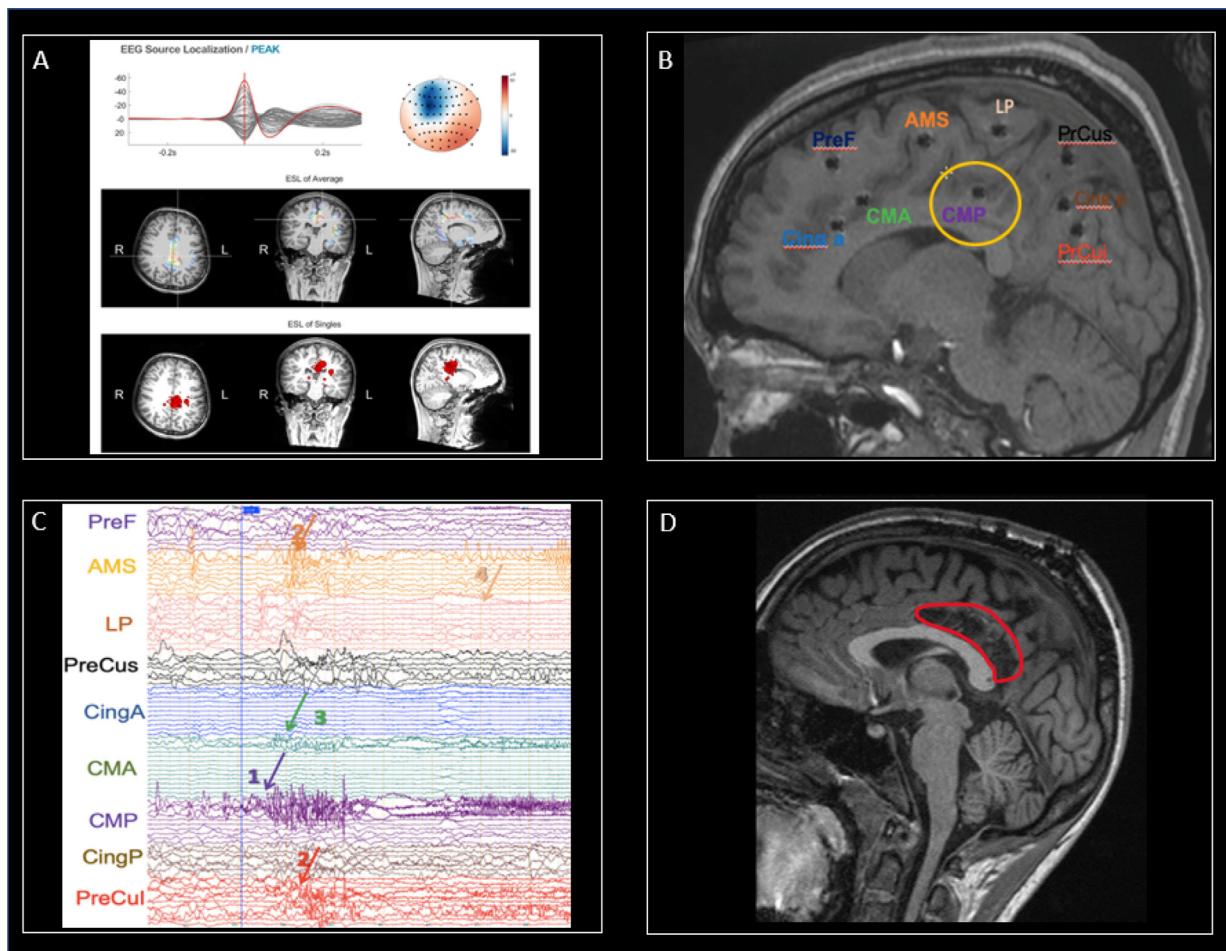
Case-study 1. A: Results of automated ESI of the first (in red) cluster, at the peak of the averaged waveform (maximum localized at the crosshair), and of the individual spikes in the cluster. Note that both the maximum of the averaged waveform, and the majority of the individual spikes (red circle) indicate a source in the left middle/posterior cingulate cortex, which is in concordance with the SEEG-SOZ and the resection site. ESI results of the other clusters and at half-rise time are similar and are not shown there; B: Modified SEEG plan suggested by ESI results, including an additional depth electrode (CMP), to cover the middle/posterior cingulate cortex (yellow circle); C: SEEG recording showing a seizure with clear onset of ictal discharges in the CMP electrode (violet arrow), followed by rapid and multidirectional propagation to AMS (dark yellow arrow), Precui (red arrow) and CMA (green arrow); D: Postoperative MRI showing a limited posterior cingulate cortectomy and sparing of the front half. Margins of resection are bordered in red. ESI cluster is included in the resection zone. The patient is seizure-free (ILAE class I) at 2-year postoperative follow-up. CingA: anterior cingulate cortex; CMA: anterior/middle cingulate cortex; CMP: middle/posterior cingulate cortex; CingP: posterior cingulate cortex; PreF: prefrontal; AMS: supplementary motor cortex; LP: paracentral lobule; PrCus: precuneus (superior part); PrCui: precuneus (inferior part).
